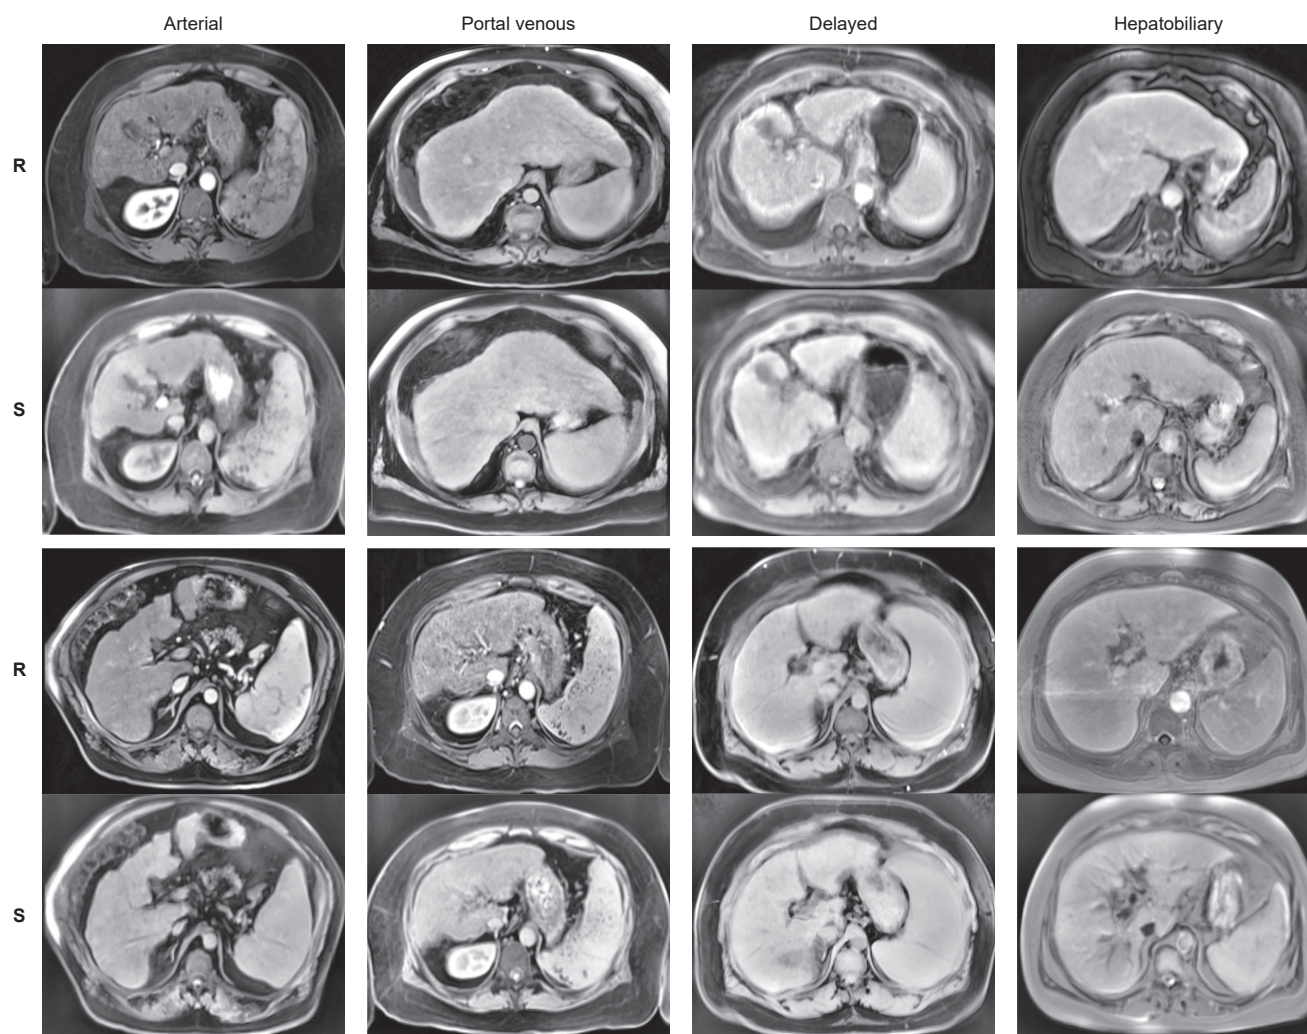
Cirrhosis ground-truth and synthetic MRI. Examples are shown of ground-truth (real) (R) and synthetic (S) liver post-contrast MRI phases of cirrhosis patients. MRI, magnetic resonance imaging.
